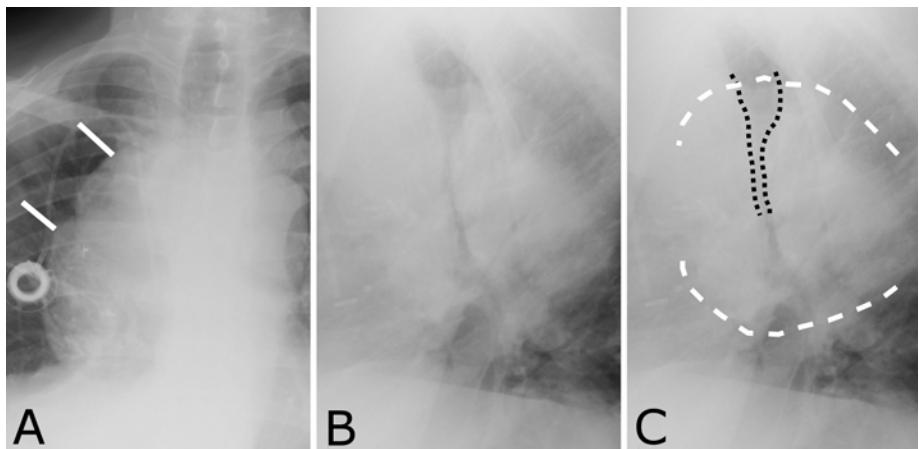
Middle mediastinal mass. A. Frontal film shows a large mass (white lines) centered in the mediastinum. B. Unmarked lateral radiograph. C. Marked lateral radiograph shows the extensive mass centered in the middle mediastinum (white lines). Notice the marked compression of the airway (black dots).
